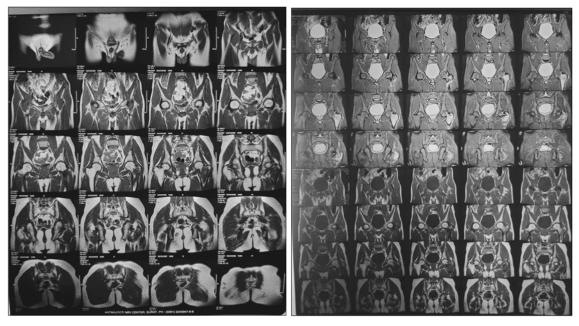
MRI on initial presentation coronal images
